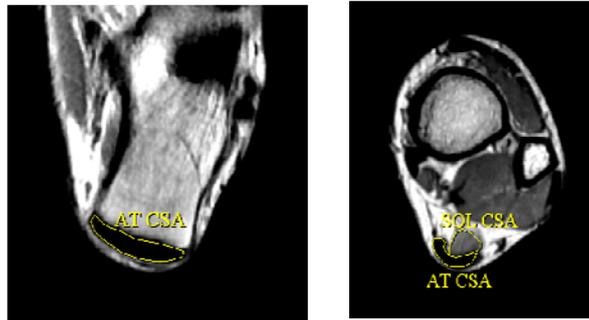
Typical examples of cross sectional magnetic resonance images.
